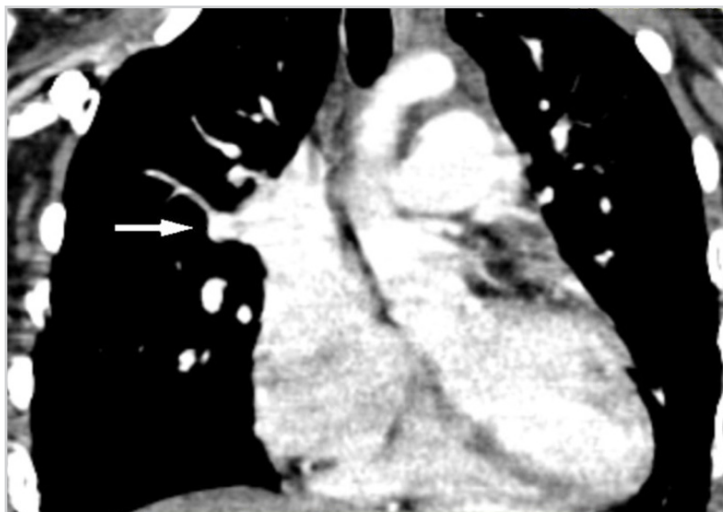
Frontal CT-section angio-cardiography of the supracardiac form of PAPVD. The arrow shows the in flow of the right pulmonary veins into the SVC
